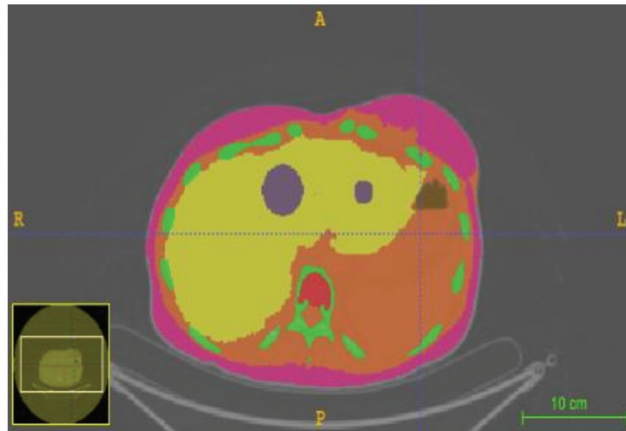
Transversal slice of the NUL-b contoured CT where tumor regions are shown in purple (BS and SS are visible in this slice).
